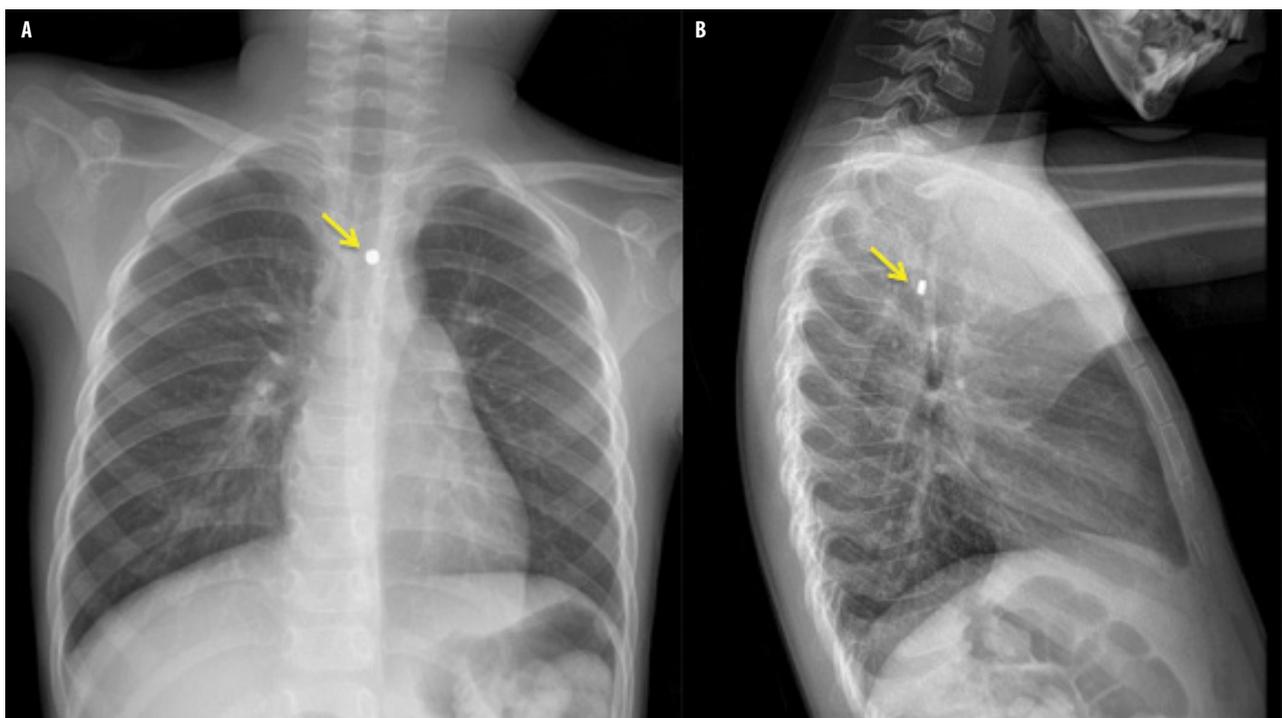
A radiopaque foreign body (yellow arrow) in the chest on antero-posterior (A) and lateral (B) views of chest radiograph
